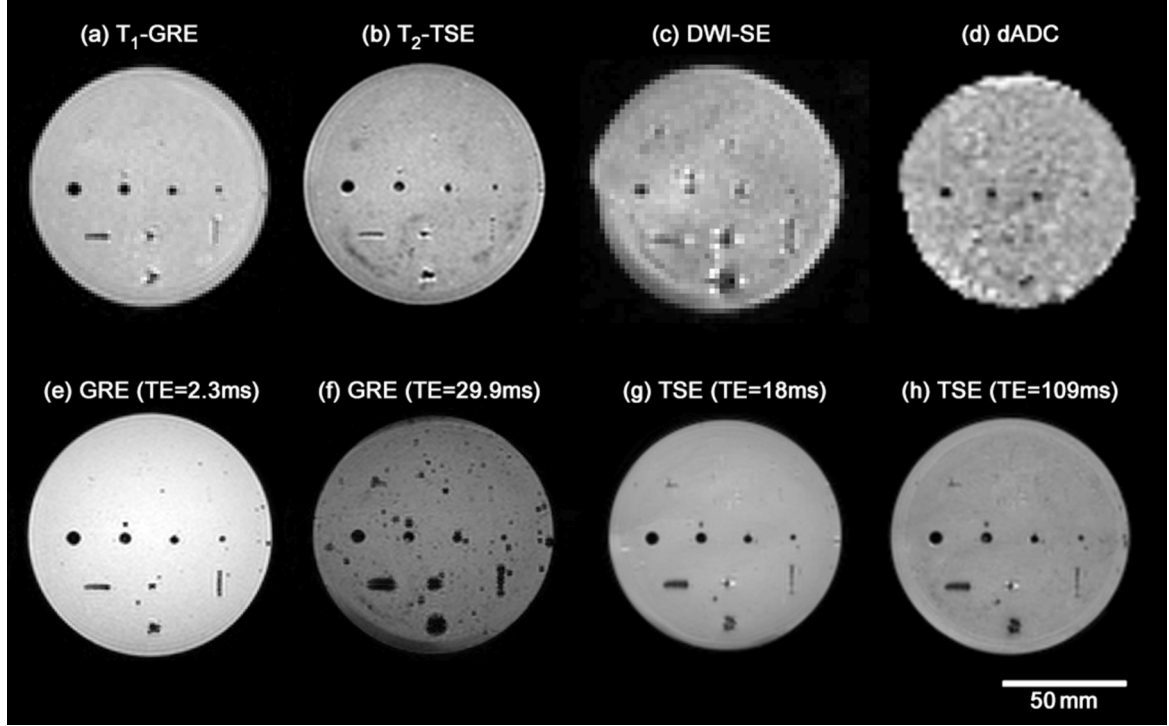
Qualitative assessment of the fiducial marker in different MRI sequences. (a) T_1 -weighted spoiled GRE, (b) T_2 -weighted SE, (c) Diffusion-weighted SE, (d) Apparent diffusion coefficient map in M-gradient direction calculated from DWI image in (c), (e-f) GRE with TE = 2.3 ms (e) and TE = 29 ms (f), (g-h) SE with TE = 18 ms (g) and TE = 109 ms (h)
